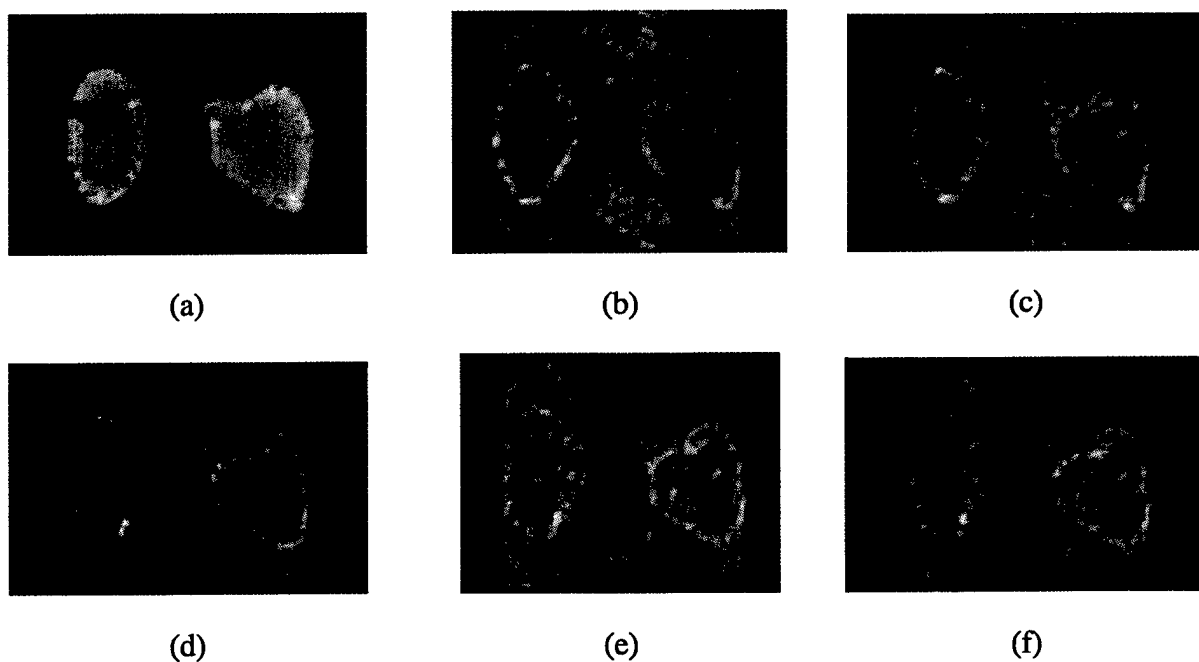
Signal enhancement of breast images in MRI: (a) pre-contrast image (b-f) 5 post-contrast images.
